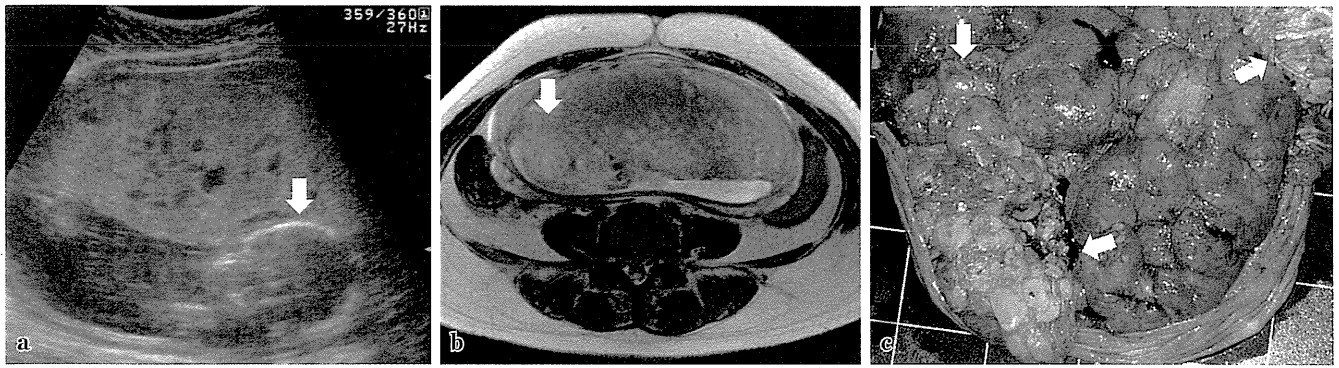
間葉性異形成胎盤(PMD)の画像診断と肉眼所見 a:経腹超音波断層法(妊娠17週5日), b:MRI T2強調画像(妊娠18週0日). 胎児(矢印)とともに肥厚した胎盤が認められる. 胎盤は均質で胎児面は平滑, 実質内に大小不整な嚢胞や管腔様構造を認める. c:肉眼所見. 妊娠31週2日, 出生体重1,116 g, 胎盤重量450 g, 胎盤胎児重量比0.40. 胎盤の胎児面には多嚢胞状の部位(矢印)と変化の乏しい部位が混在している. (北海道大学産科・周産母子センター 山田崇弘博士より提供)
